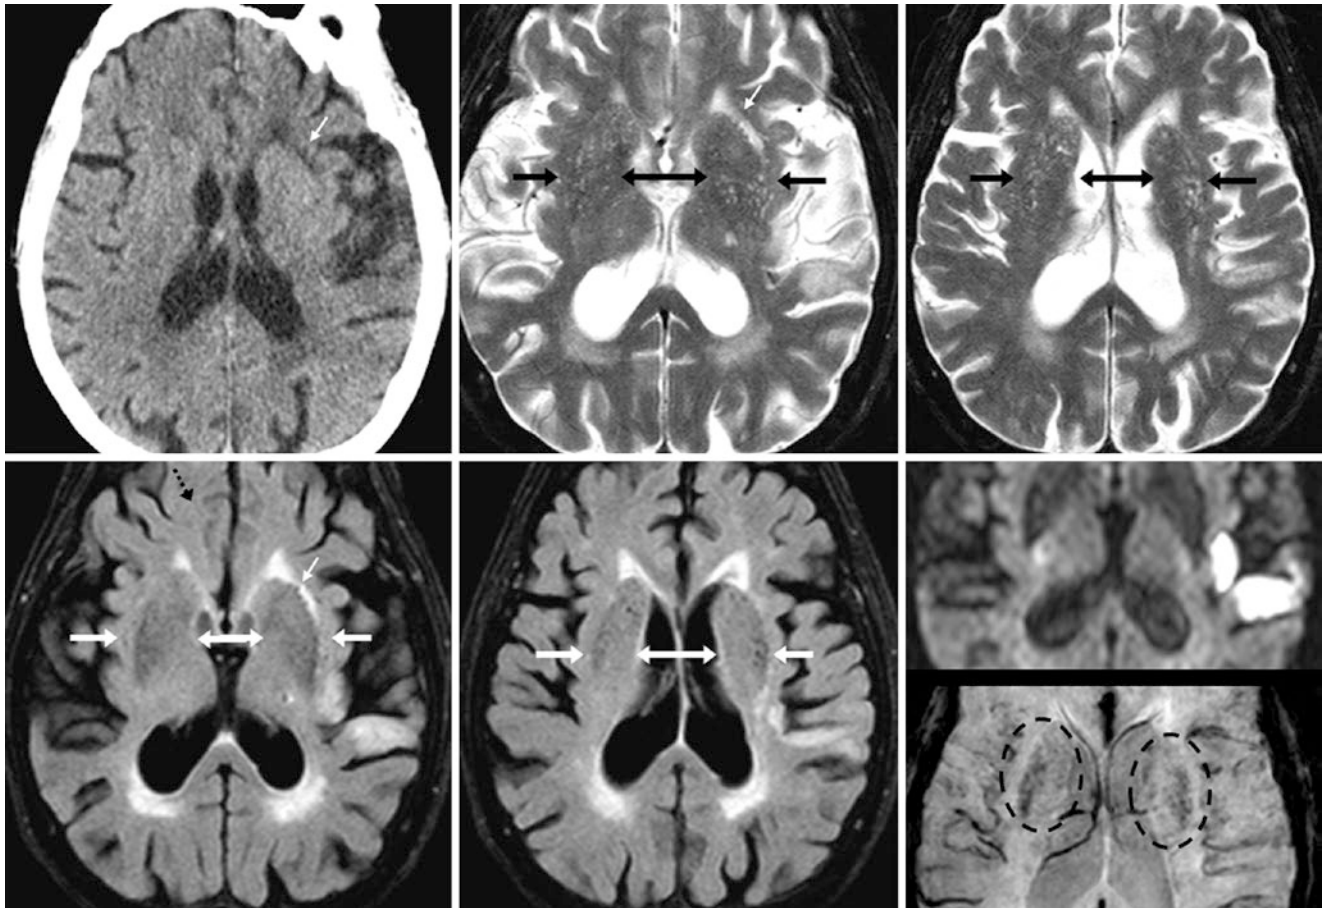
A 92 year old had cribriform tiny PVSs (*between arrows*) throughout the basal ganglia (*état criblé*), on NECT (*top left*) and T2WI MRI (*top, middle, and right*). The PVSs mostly suppress on FLAIR (*bottom, left, and middle*); note encephalomalacia anteriorly (*tiny arrows*). DWI shows a new acute infarct (*bottom right, top image*). SWI
